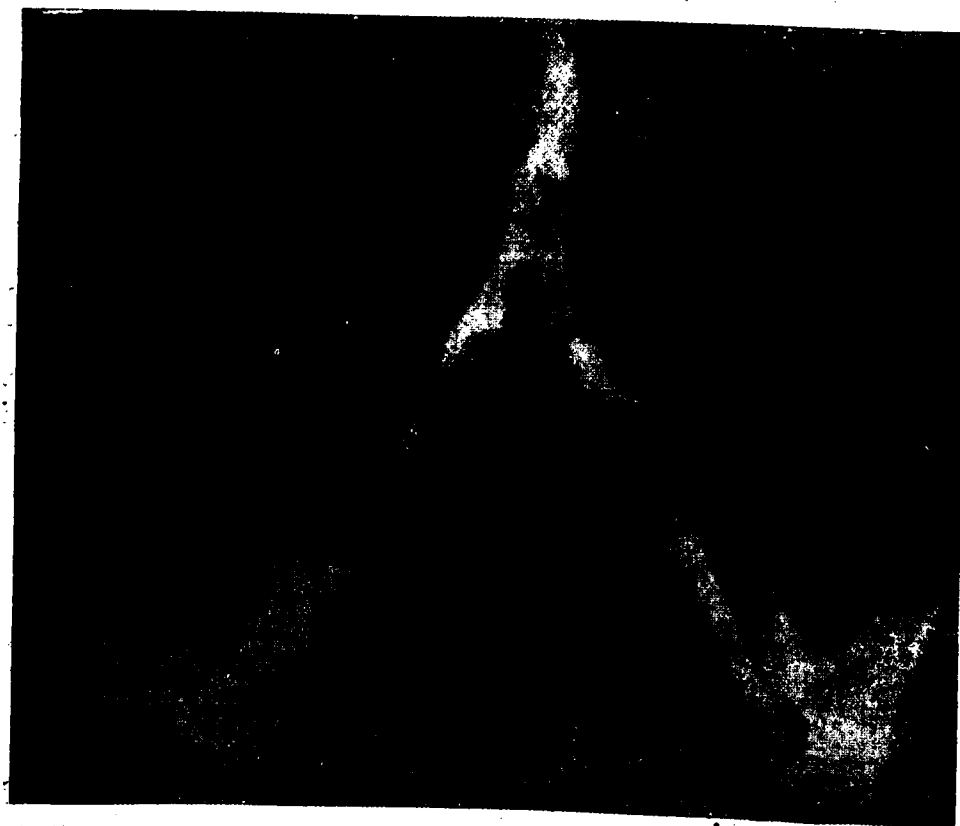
Radiograph of injected arteries showing level of bifurcation of the common iliac arteries.
